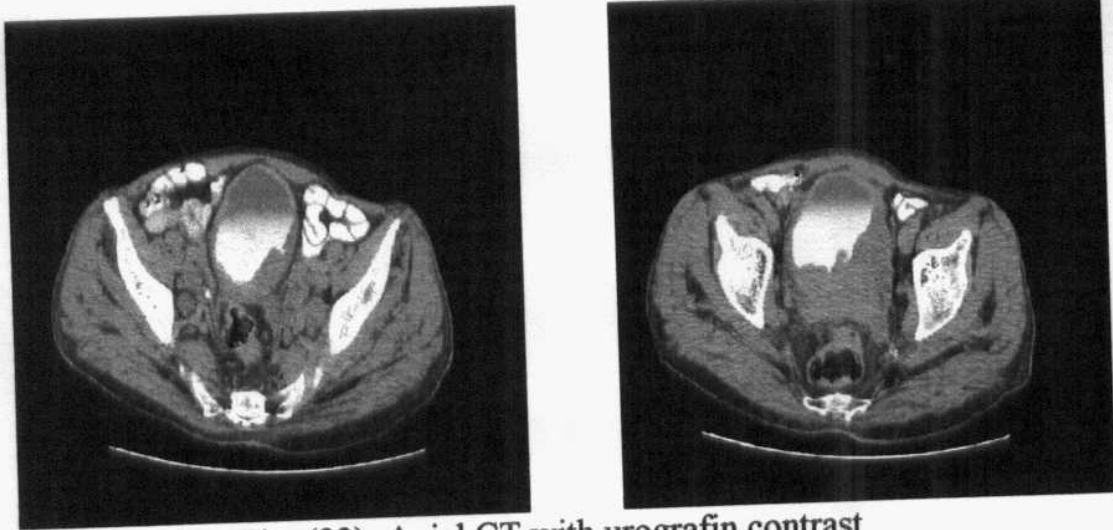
Axial CT with urografin contrast.
